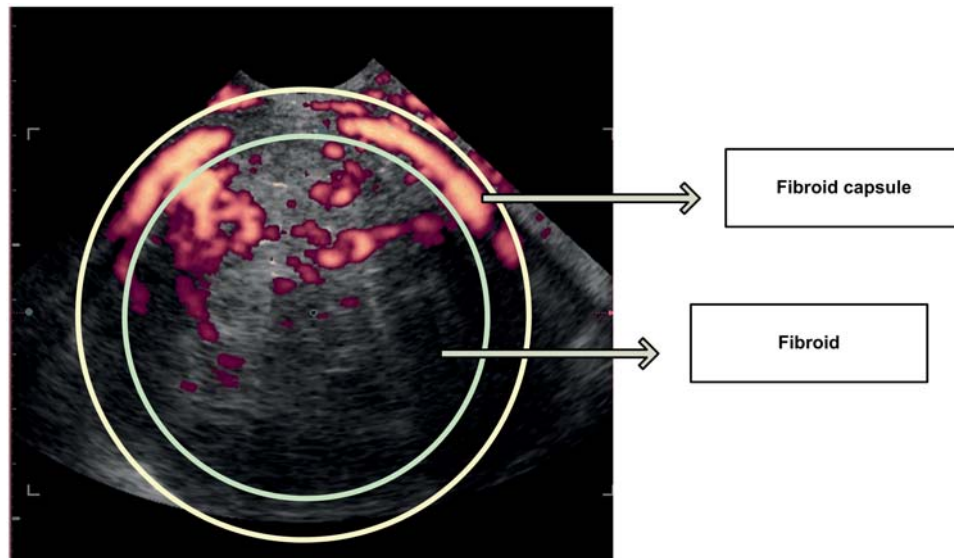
3D Power Doppler image: well vascularised fibroid, moderate peripheral penetration
